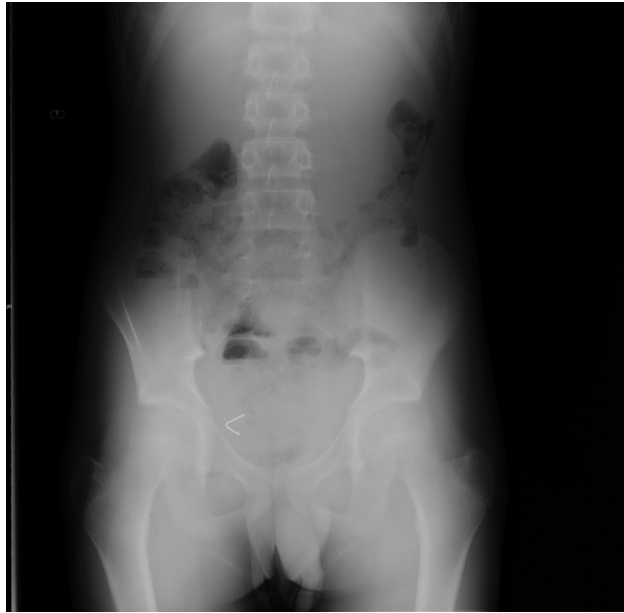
Plain radiograph of the abdomen.
